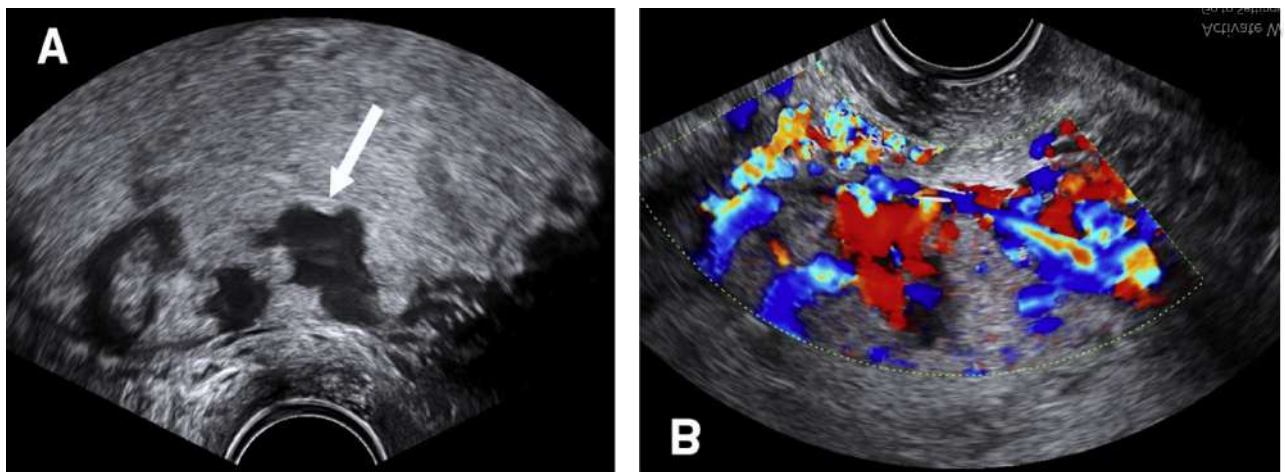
Transvaginal ultrasound views of placenta previa increta at 20 weeks.
